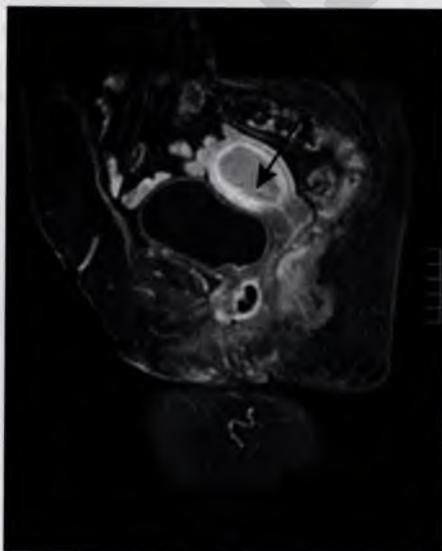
Magnetic resonance image of the pelvis showing an endometrial cancer infiltrating the myometrium (arrow).
